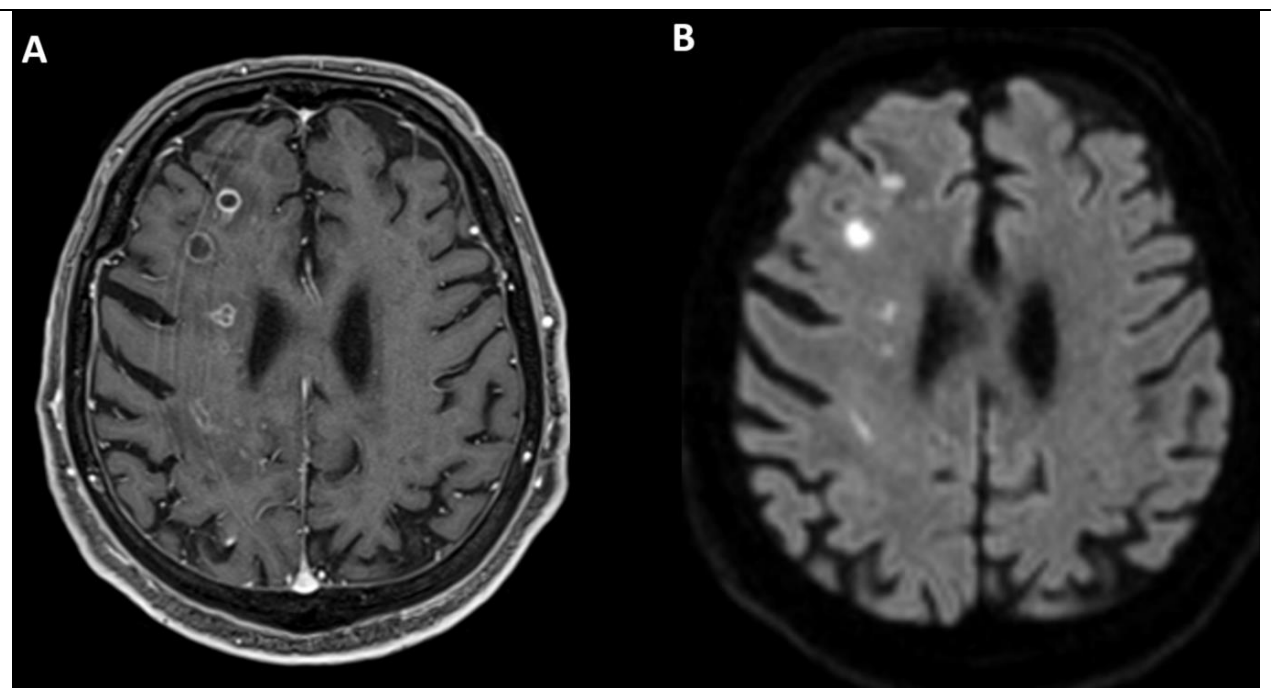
Brain MRI, axial contrast-enhanced T1 weighted image (A) and diffusion-weighted image, DWI (B). Multiple small intra-axial ring-enhancing lesions in the right cerebral hemisphere, localized both at the cortico-subcortical junction and in the deep white matter in the frontal and parietal lobes (A). All the lesions show hyperintensity at DWI (confirmed at ADC map, not shown).
